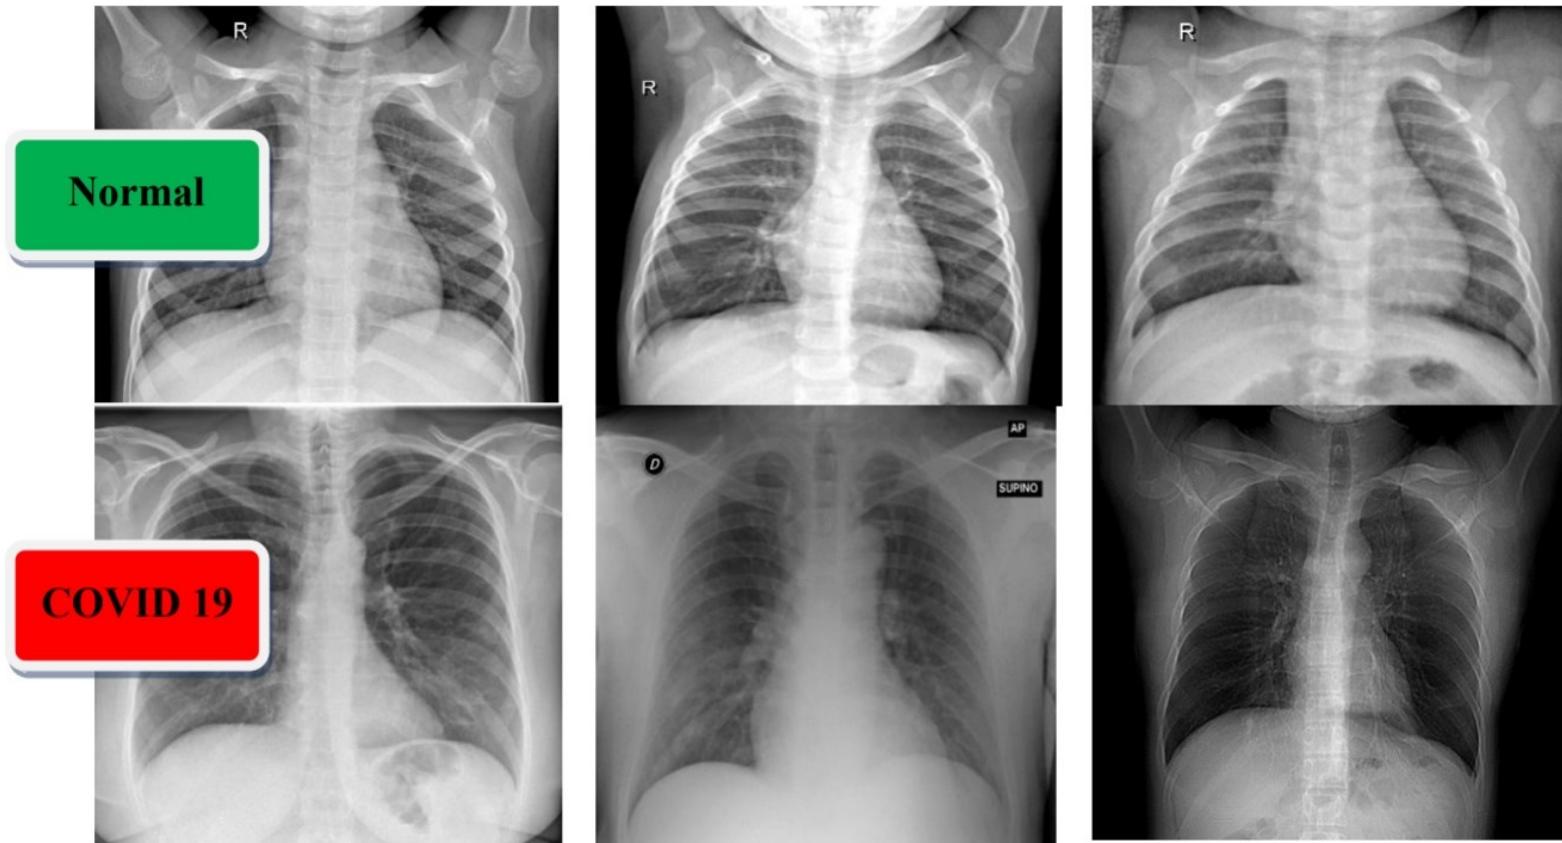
A sample of X-ray images dataset for normal cases (first row) and COVID-19 patients (second row).
